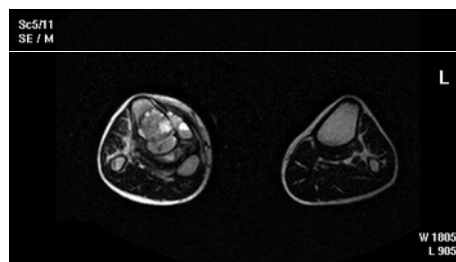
MRI horizontal plane.
